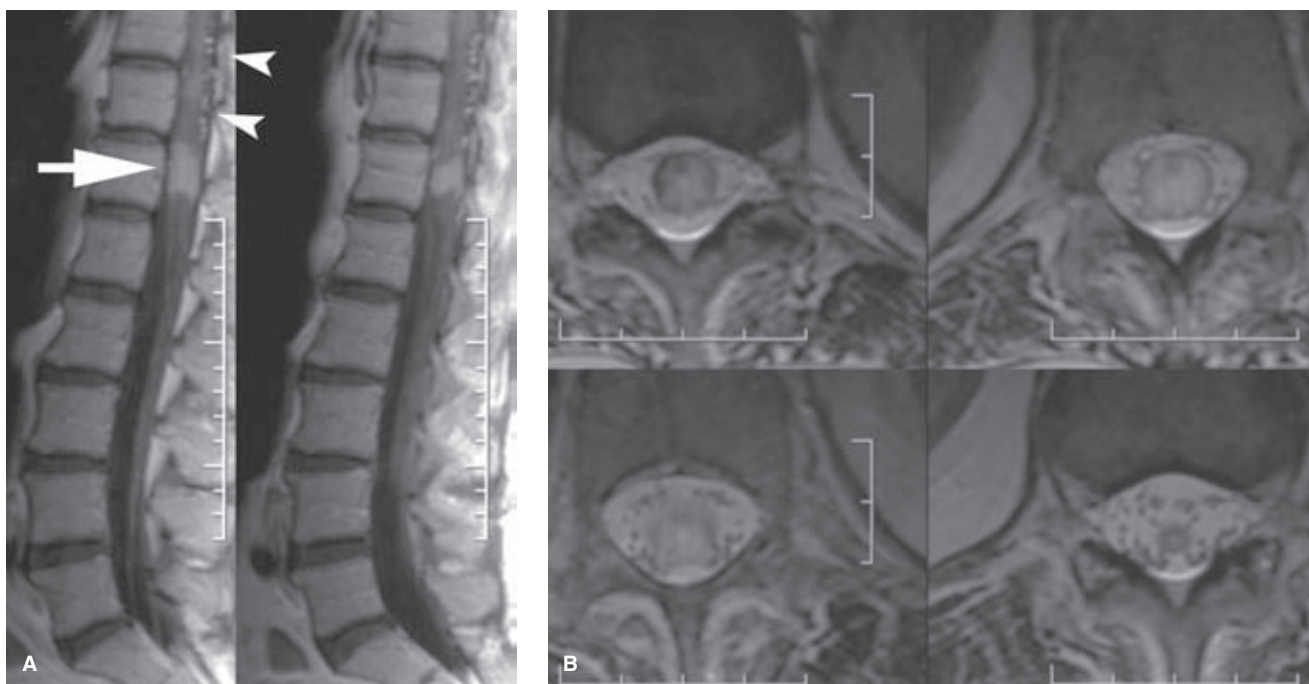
(A–E) Spinal arteriovenous malformation with venous hypertension (Foix–Alajouanine) mimicking a conal mass. An 83-year-old female with a remote history of breast carcinoma presented with progressive lower extremity weakness and sensory disturbance. An enhancing mass on her sagittal T1 gadolinium-enhanced MRI (*arrow in A*) prompted the diagnosis of metastatic carcinoma to the cord. The axial T2 MRI (B) seemed to confirm the expansile hyperintense appearance of the cord. However, she had no other history of metastatic disease, and a prominence of vascular structures (*arrowheads in A*) on the dorsum of the cord suggested that an arteriovenous malformation might be a consideration. The anterior spinal artery at left T9 shows indirect signs of disease. (*continued*)
